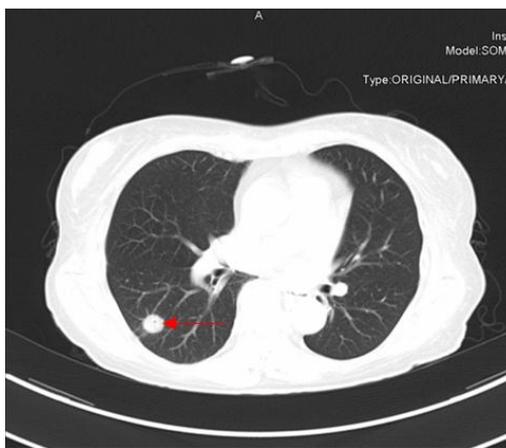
33 months after surgery. There was no change of the metastases as showed on the CT of the chest (red arrow)). However, the abdomen CT showed the mass of abdominal cavity increased to 7.8cm in diameter (white arrow).
